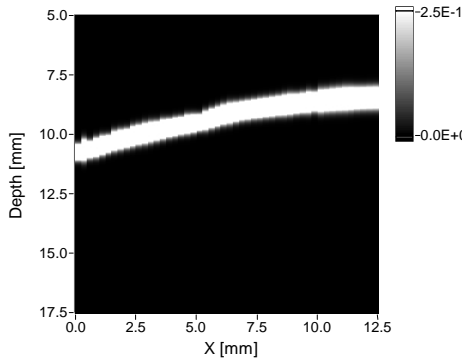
Photoacoustic image of a 1 mm diameter artificial blood vessel (silicone rubber tube), filled with flowing human blood. The scan consisted of 51 measurement positions, with a spacing of 0.25 mm. In this measurement a pulse energy of 1 mJ/pulse is used, pulse-duration 8 ns, at a wavelength of 800 nm. All signals were averaged 128 times. Per measurement position (vertical line in 2D image), the signals were normalized to the maximum value, to correct for the decrease in amplitude, due to a decrease in light intensity with increasing depth, and geometrical attenuation of the ultrasound, together with the depth response of the photoacoustic sensor.
